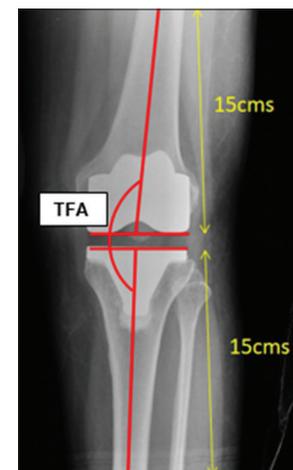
Tibio-femoral angle (TFA) measurement on conventional knee radiograph
